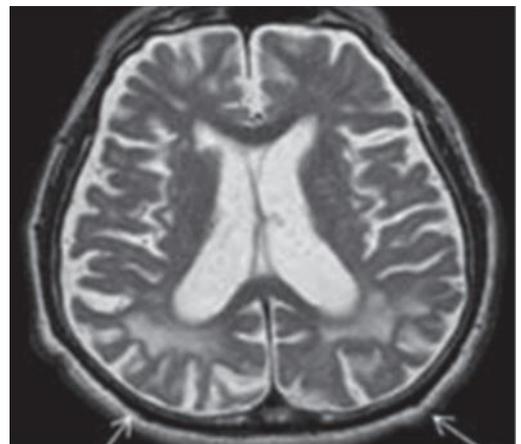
Brain magnetic resonance imaging appearance of cerebral small vessel disease (Wardlaw et al., 2013).
